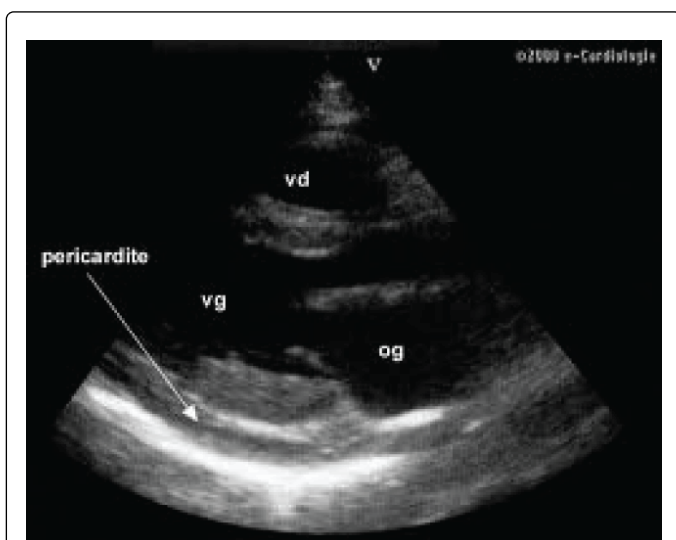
Echocardiography showing pericardial effusion abundance of small longitudinal section major axis.
